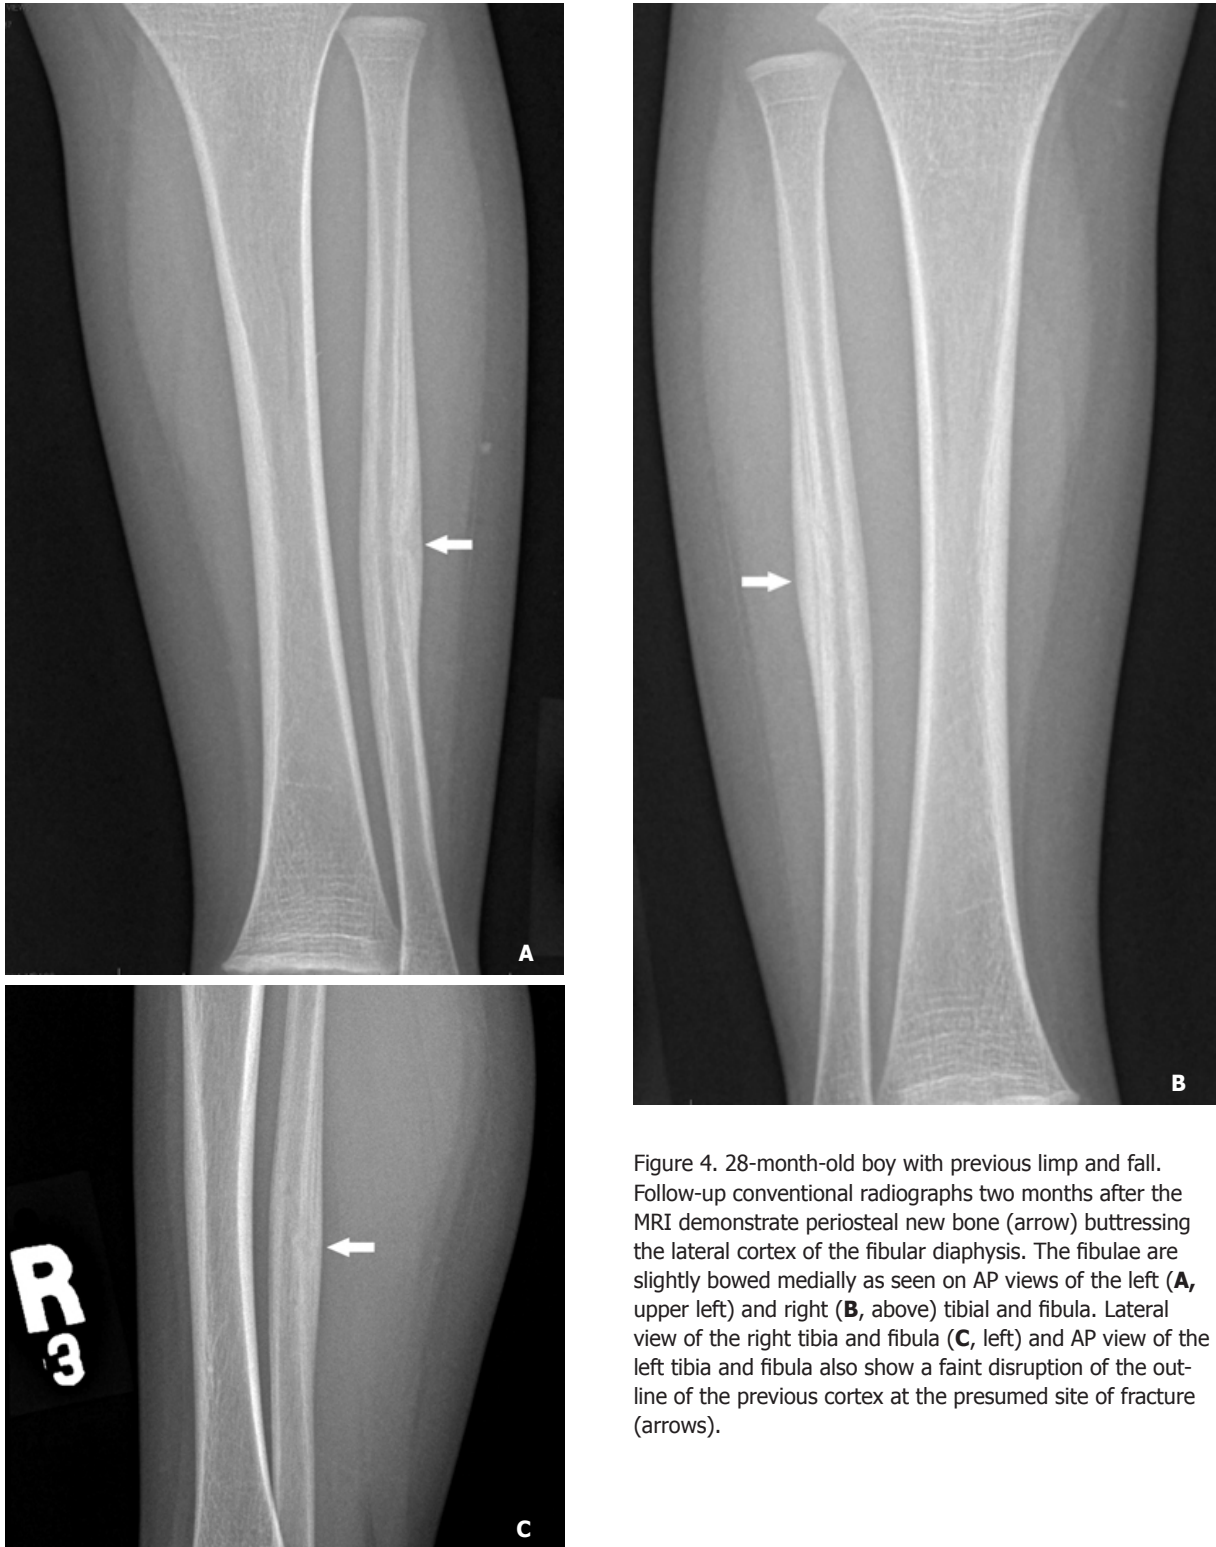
28-month-old boy with previous limp and fall. Follow-up conventional radiographs two months after the MRI demonstrate periosteal new bone (arrow) buttressing the lateral cortex of the fibular diaphysis. The fibulae are slightly bowed medially as seen on AP views of the left (A, upper left) and right (B, above) tibia and fibula. Lateral view of the right tibia and fibula (C, left) and AP view of the left tibia and fibula also show a faint disruption of the outline of the previous cortex at the presumed site of fracture (arrows).
